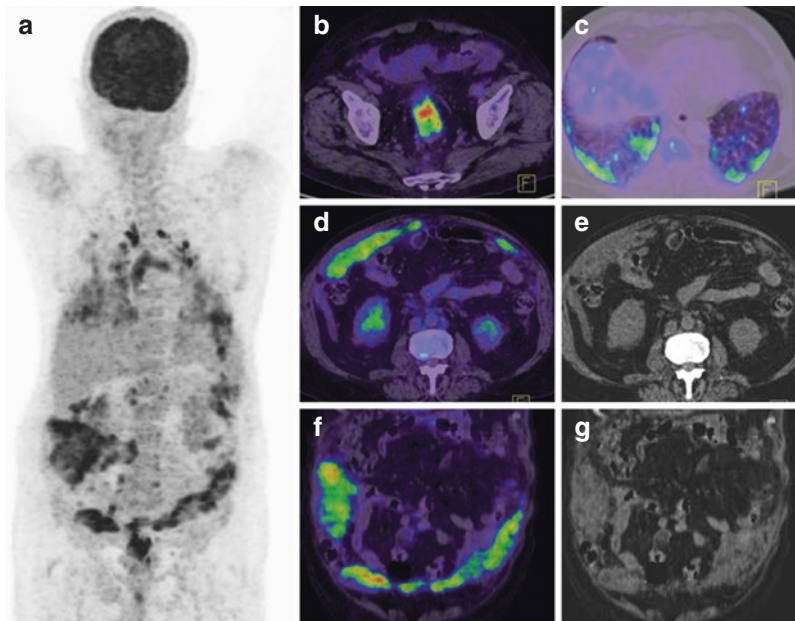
A 66-year-old man with carcinoma of the rectosigmoid, 18F-FDG PET/CT shows intense FDG avid primary site (b), extensive intensely FDG-avid omental nodules and omental thickening (d-f) with FDG avid lung lesions (c) and mediastinal lymph nodes
